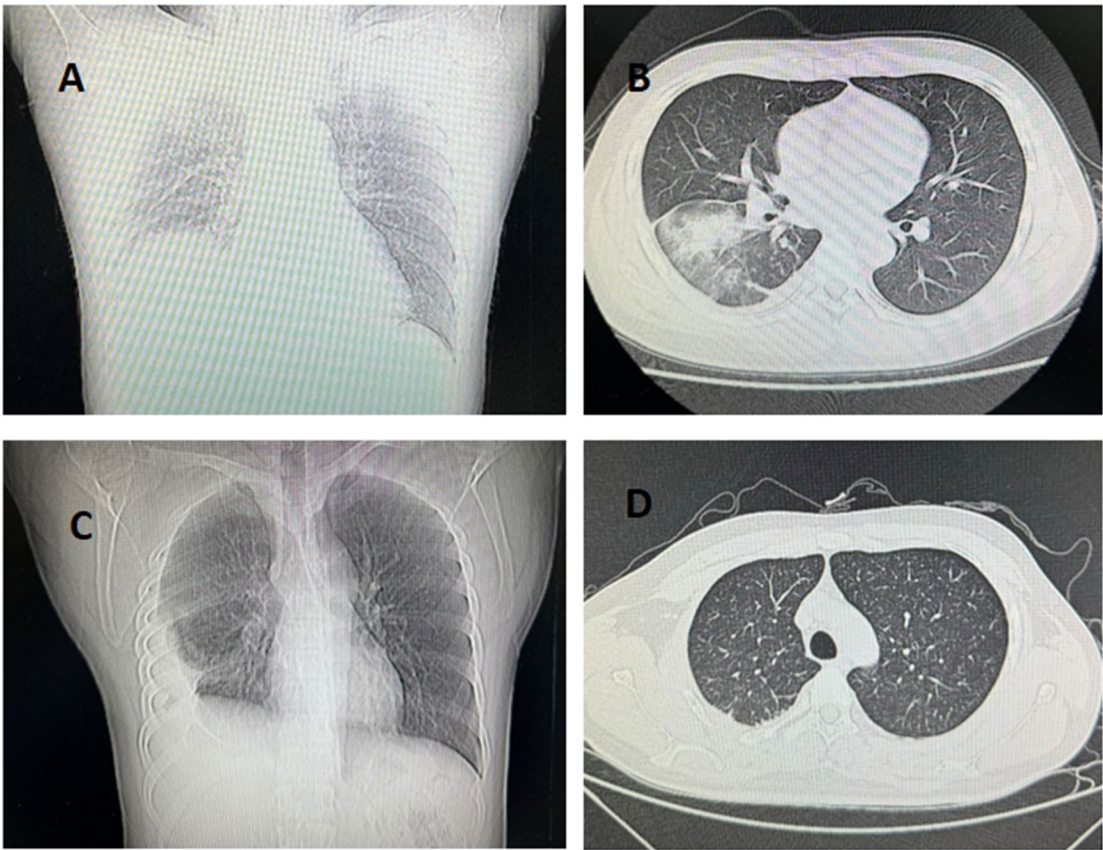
Chest CT images. A, B: Multiple inflammations in both lungs with partial consolidation; C, D: Improvement of lesions in the lower lobes of both lungs after identifying the cause and administering appropriate treatment
